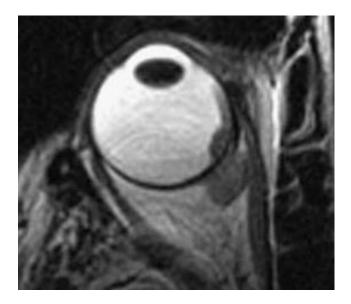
MRI image of axial length (Adapted from MRI Techniques and Protocols).
